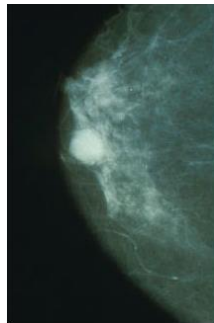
Sample Input X-ray image
